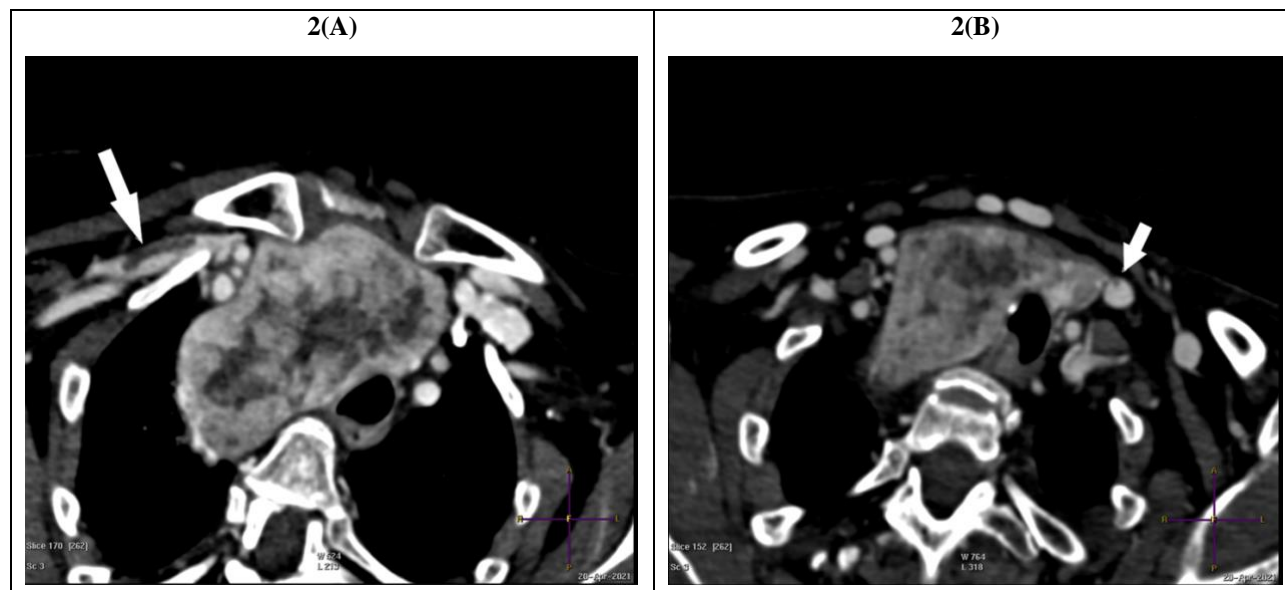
Computed tomography images show (A): thrombosis of right subclavian vein (white arrow); and (B): thrombosis of left internal jugular vein (white arrow).
